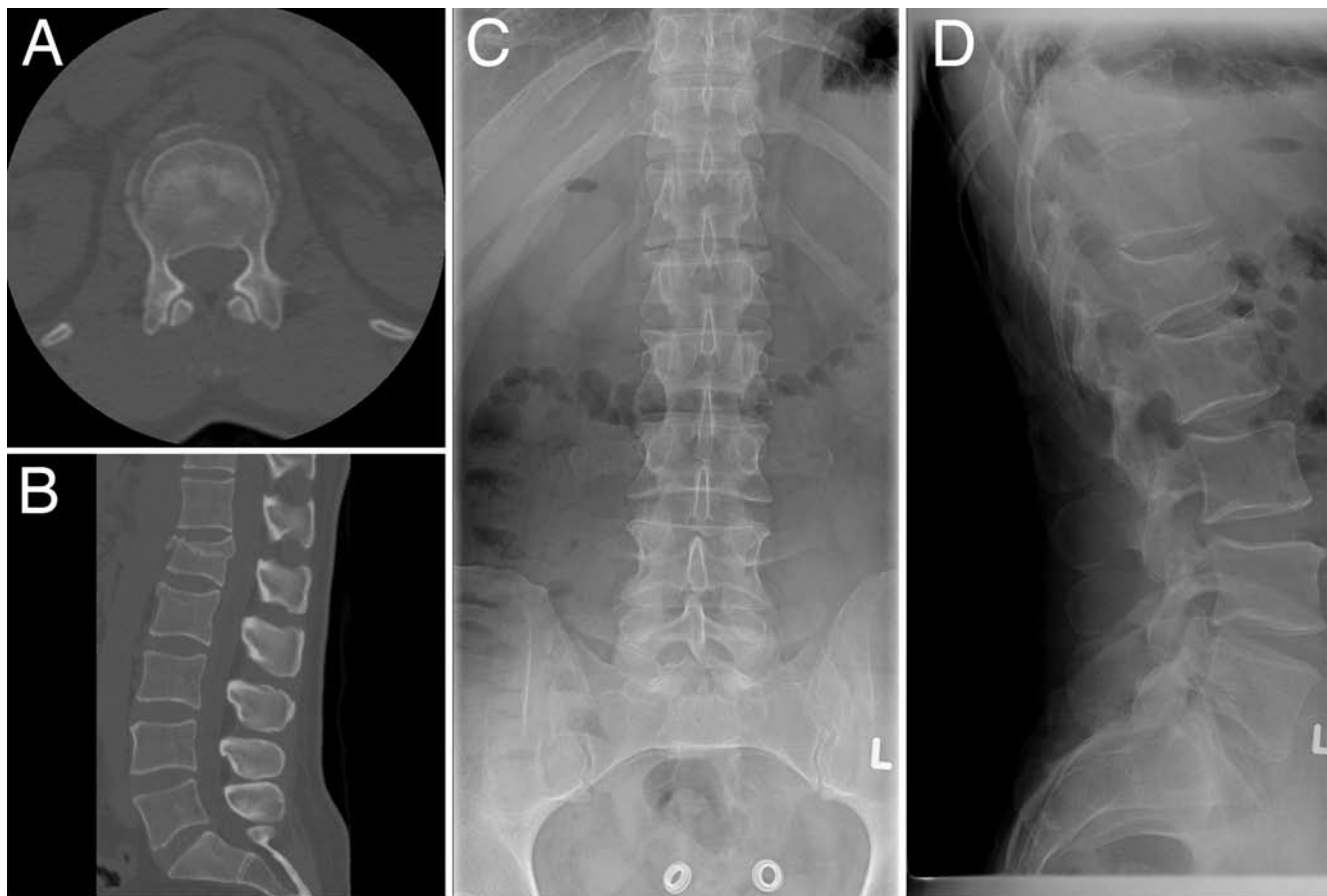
Representative imaging studies in a 48-year-old man: axial (A) and midsagittal (B) CT scans obtained at the time of injury and AP (C) and lateral (D) radiographs acquired at 6 weeks follow-up. Kyphosis was 3° at 6 weeks postinjury measured laterally in a standing position.
